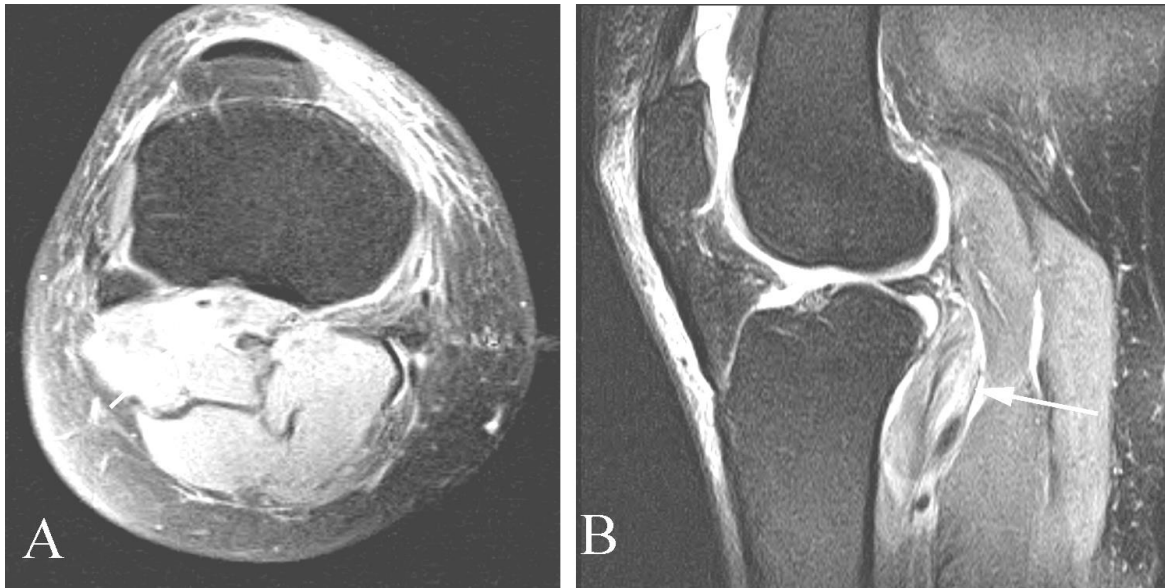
Popliteal muscle tear in a 48 year old man with pain following trauma. A. Axial fat-suppressed T2 weighted image shows abnormal signal and swelling of the popliteus muscle (arrow), compatible with a strain (partial thickness musculotendinous tear). B. Sagittal fat-suppressed T2 weighted MR imaging also demonstrates abnormal signal and swelling of the popliteus muscle (arrow).
